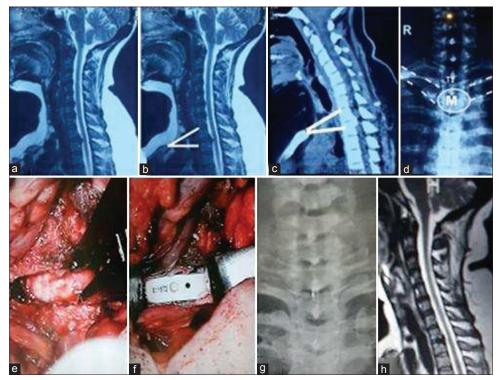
(a) T2-weighted sagittal magnetic resonance imaging (MRI) of the second case showing a hard disc at T1–T2 level. (b) The disc space is a little bit above the manubrium line and cervicothoracic (CT) angle is 27° . (c) Reconstructed sagittal computed tomography (CT) scan of the CT region showing T1–T2 hard disc, indicating that the compression, also note that CT angle is 10° . (d) Chest X-ray shows that T1–T2 disc is a few mm above the manubrium. (e) Intraoperative clearance of the disc space from both hard disc and osteophytes. (f) After placement of a large cage. (g) Plain CT radiograph showing that the cage is located at bicalvicular line. (h) Postoperative T2-weighted MRI: showing appropriate decompression of the spinal cord at T1–T2 level.
